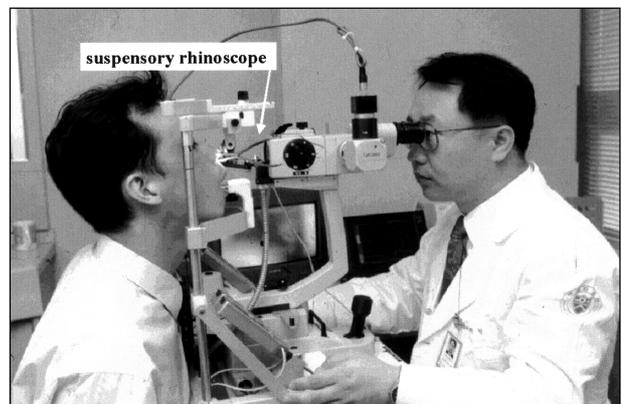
Real view of measuring nasal blood flow with Laser Doppler Flowmetry : After patient's head was fixed, inferior turbinate was exposed with suspensory rhinoscope.
